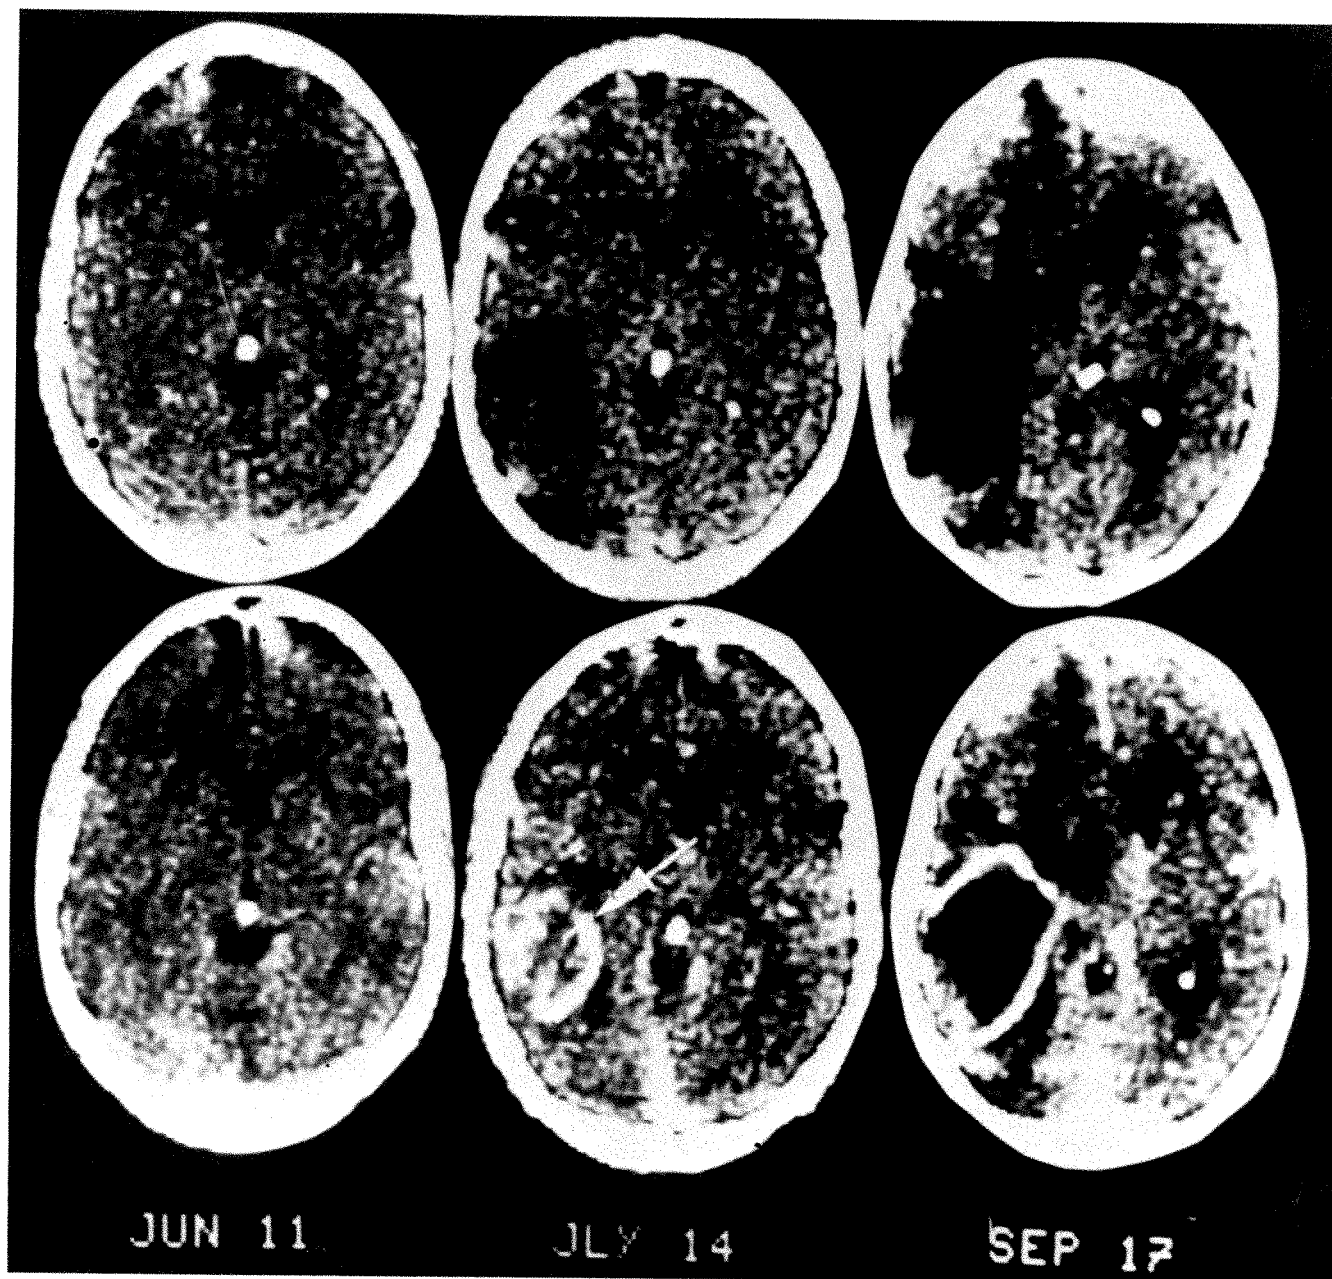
Glioblastoma. CT scans without contrast (*upper*) and after 300 ml meglumine diatrizoate (*lower*). *Left*, Normal study. *Center*, Scan 1 month later showing left temporal abnormality with definite enhancement (*arrow*). *Right*, Scan 2 months later showing marked progression.
